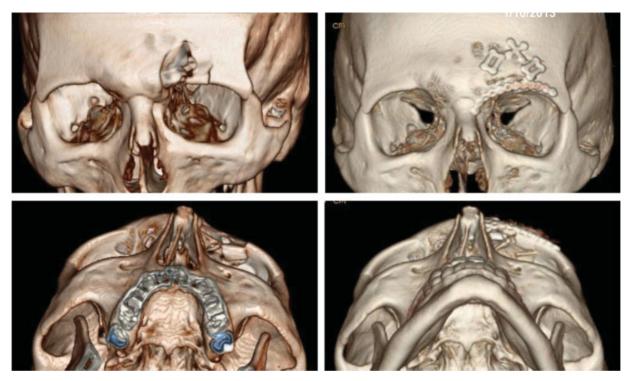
Comparison of preoperative and postoperative three-dimensional computed tomography scans demonstrating correction of the depressed frontal sinus fracture for the same patient described in Fig. 2 and Fig. 3. Reconstruction demonstrates excellent correction of the contour defect.
